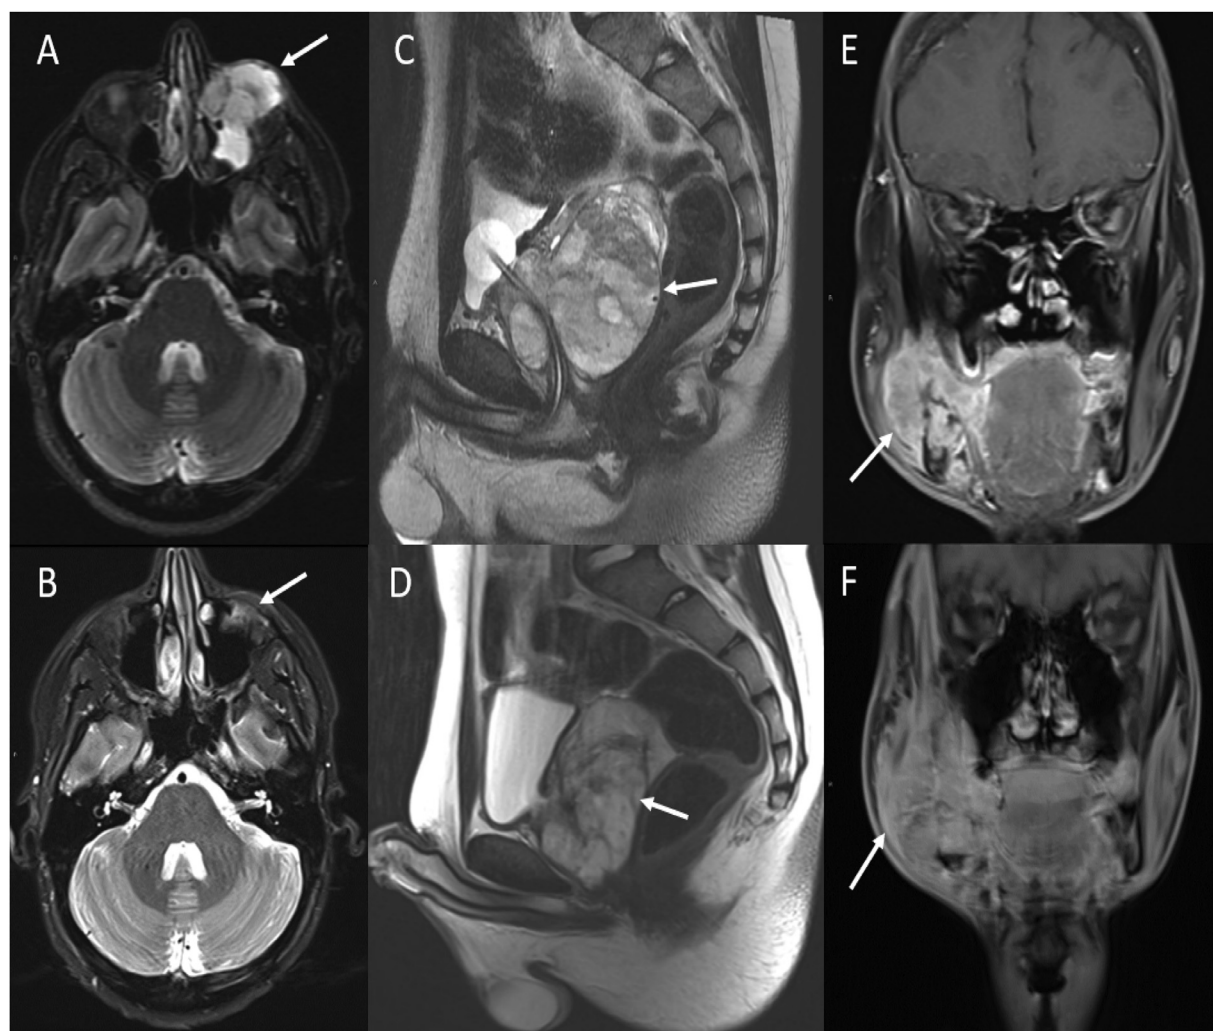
Pre- and posttreatment magnetic resonance imaging images of 3 tumors with different patterns of volumetric changes. (A) Pretreatment axial STIR image shows a hyperintense and diffusely enhancing periorbital alveolar RMS (arrow), and (B) posttreatment axial T2-Dixon shows near complete resolution of the lesion with thin peripheral enhancement (arrow) of the cavity (RVC = -100%). (C) Pretreatment sagittal T2 STIR image shows a heterogeneous prostatic embryonal RMS (arrow), and (D) posttreatment sagittal T2 STIR image shows a smaller lesion (arrow) in comparison (RVC = -60.9%). (E) Pretreatment coronal T1 fat-suppressed postcontrast image shows a heterogeneously hyperintense diffusely enhancing embryonal RMS in the right mandible (arrow), and (F) posttreatment coronal T1 fat-suppressed postcontrast image shows interval increase in size and heterogeneity of the mandibular lesion (arrow) with continued diffuse enhancement (RVC = 197%). *Abbreviations:* RMS = rhabdomyosarcoma; RVC = relative volume change; STIR = short tau inversion recovery.
